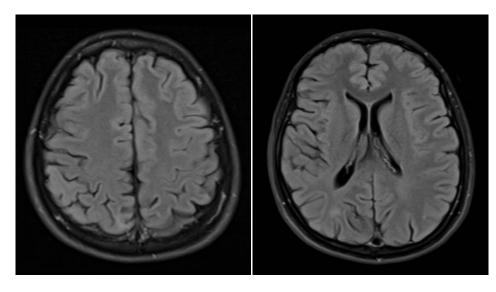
Magnetic resonance imaging of the brain done 6 months after anti schistosomal therapy given, showing nearly complete resolution of the previous lesions. right cortico-parietal gyriform pattern lesions with spotty nodular and curvilinear enhancement, as well as adjacent focal leptomeningeal enhancement (*Fig. 2*). These findings were suggestive of a parasitic infection, in particular schistosomiasis.
